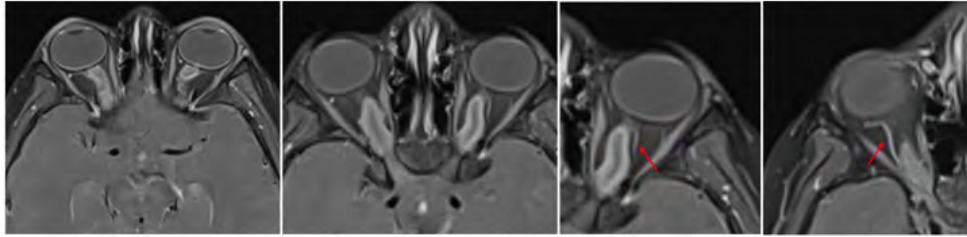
Injected orbital sequences. On T1-weighted sequences with fat saturation, the enhancement of the optic nerves is noticed and the red arrows show the satisfactory and opacified appearance of the ophthalmic arteries bilaterally.
